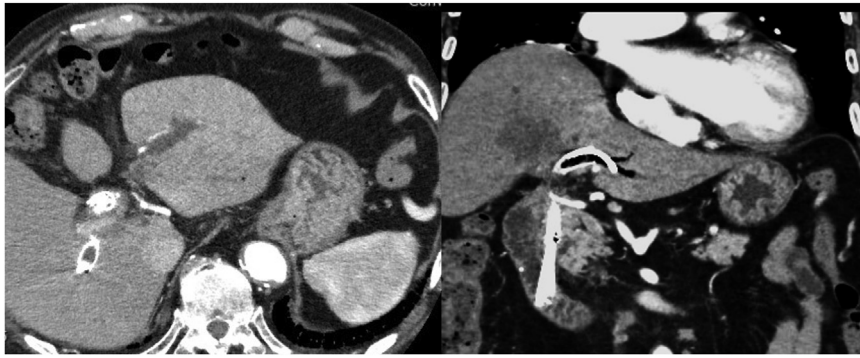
CT showed dilated intrahepatic bile ducts and an enlarged tumor involving the hilar region.
